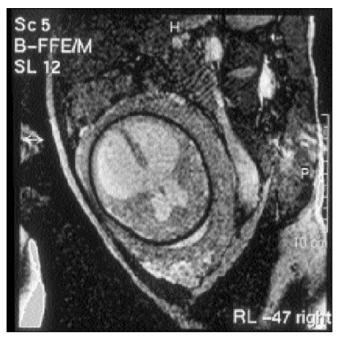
Intrauterine MRI of the baby.
